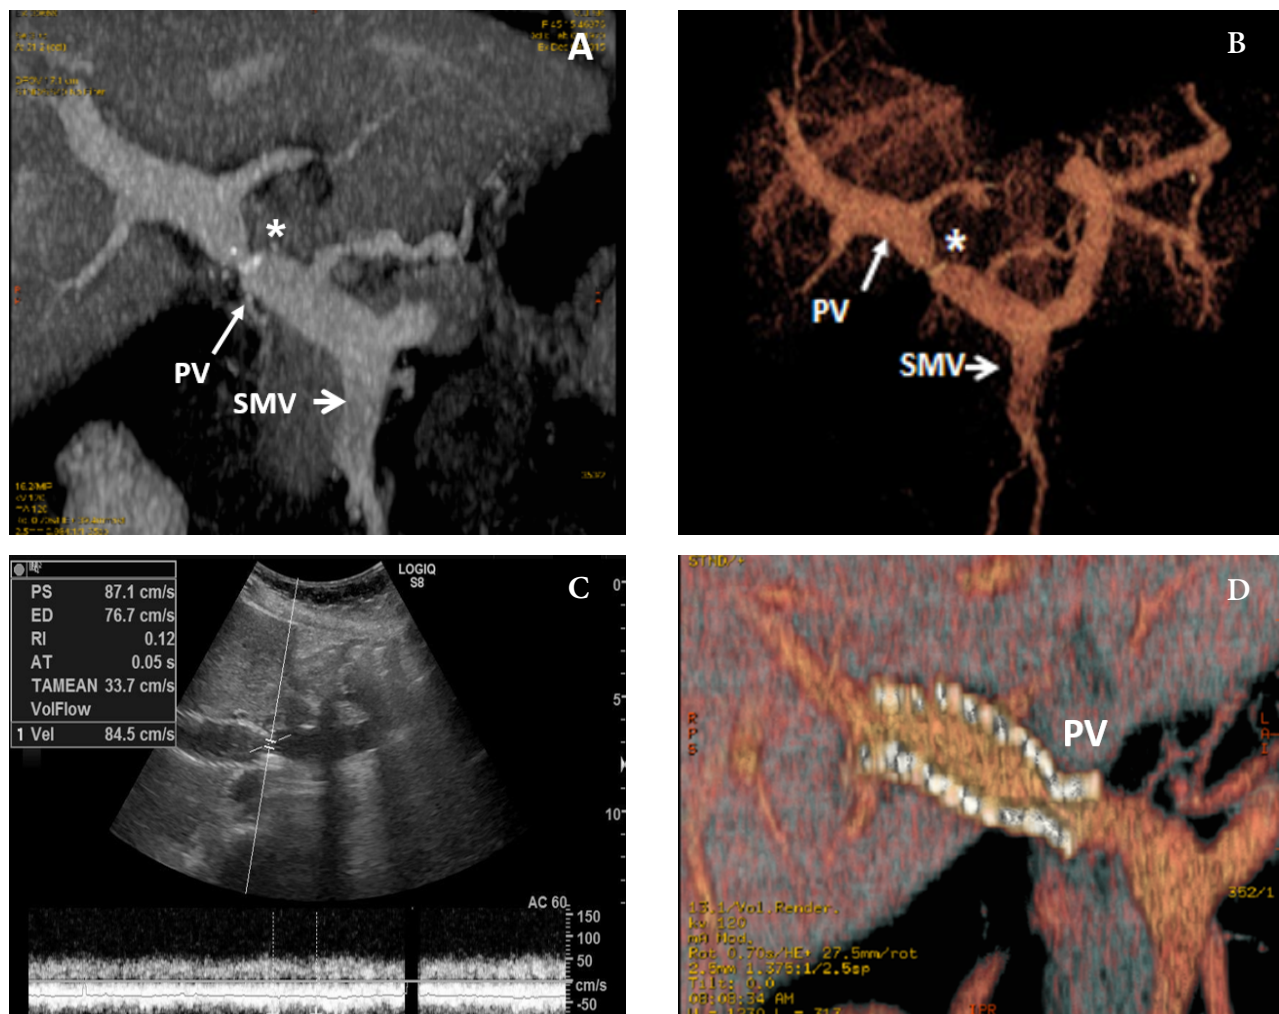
Female patient, 45 years old, one week after liver transplantation. Portal vein stenosis occurred (asterisk) diagnosed. A. CT portovenous phase, maximum intensity projection (MIP), portal vein stenosis up to 70 %. B. CT portovenous phase 3D reconstruction. PV –portal vein, SMV – superior mesenteric vein. C. Ultrasound duplex scan image. The same patient after stenting procedure, normal blood flow velocity at the anastomosis site. D. CTA portovenous phase, 3D reconstruction, stent in portal vein. CT – computed tomography; PV – portal vein; SMV – superior mesenteric vein.
